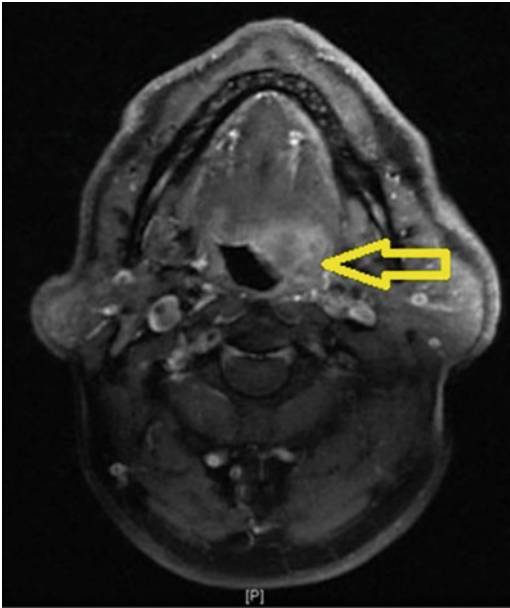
Contrast-enhanced T1 MRI image showing an infiltrative tumor over the left base of tongue (arrow)
